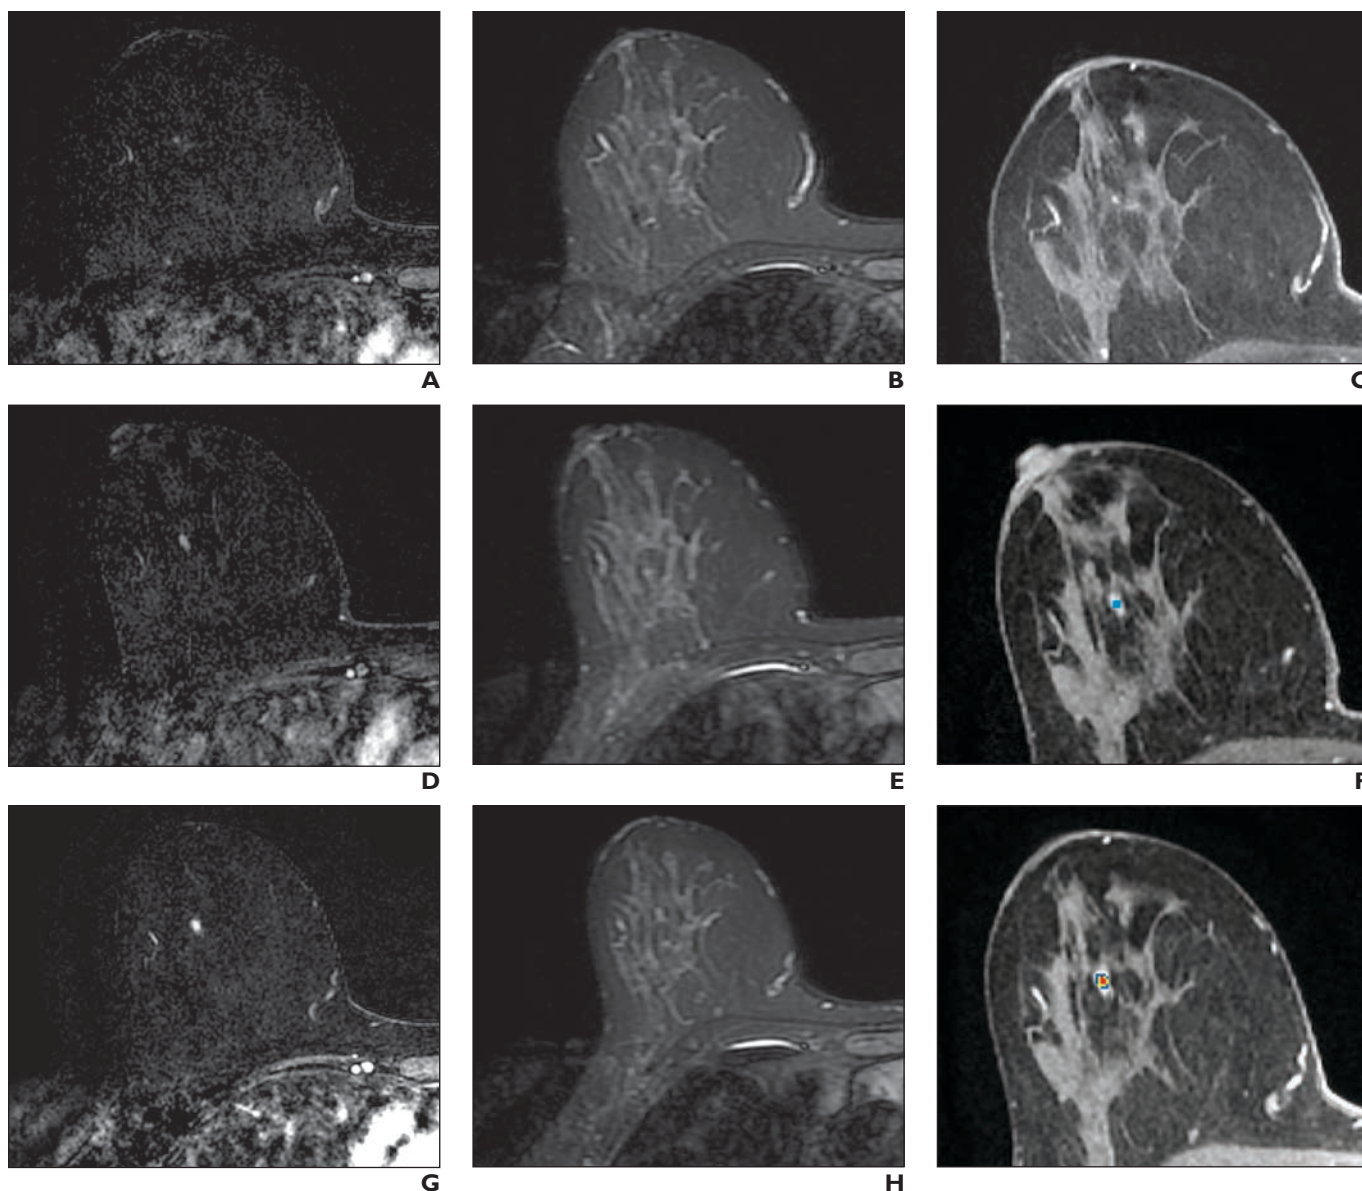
50-year-old woman undergoing high-risk screening MRI with history of left breast atypical ductal hyperplasia after excision and family history of breast cancer. Only right breast is shown.
